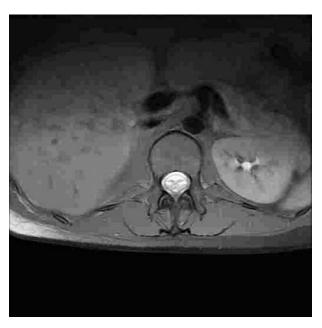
Axial T1-weighted MRI after intrathecal Magnevist injection shows epidural contrast leakage.
